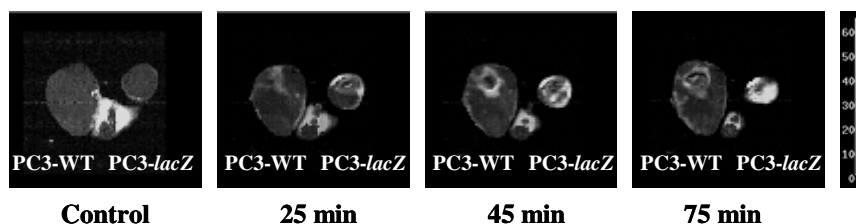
¹H MRI, 200 MHz, TR=250ms, TE=12ms, 1.5mm slice, 128×64, 40×40 mm². (A) control; (B) M₁₀ (0.4 mmol/kg), FAC (0.2 mmol/kg), PBS/DMSO (1:1), i.v. injection].
